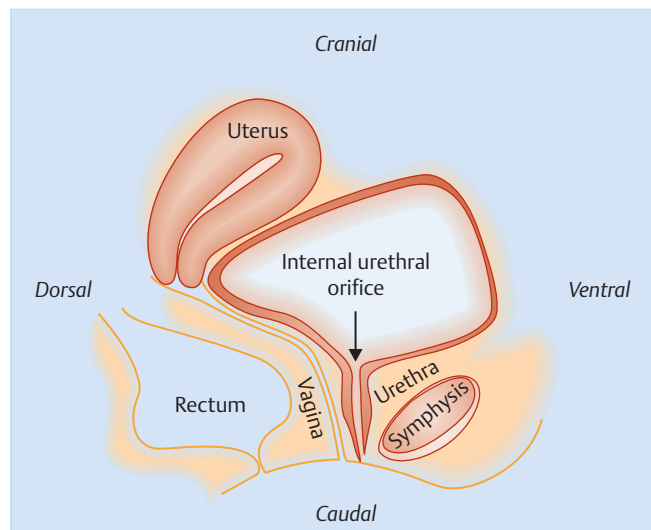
Ultrasound of the urogenital system; imaging is done in accordance with the recommendations of DEGUM, IUGA and ICS. Cranial structures are shown in the upper part of the picture and caudal structures in the lower part. Ventral structures are shown on the right and dorsal ones on the left.
